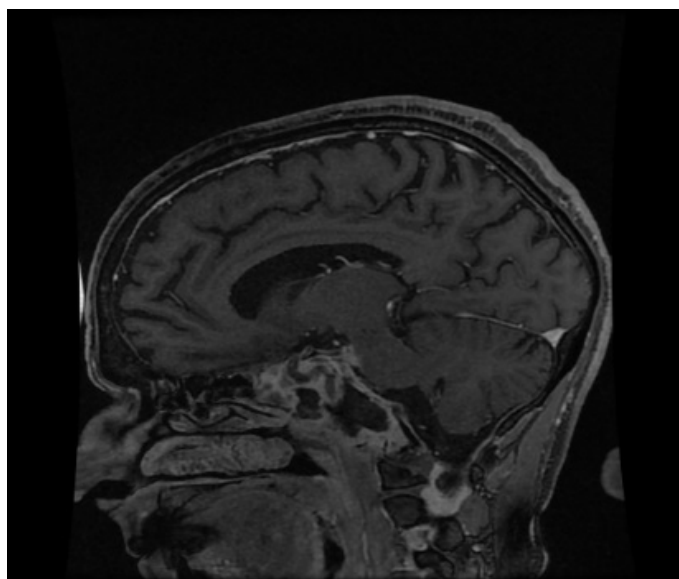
Contrast T1W MRI showing soft tissue enhancement seen at sphenoid sinus, clivus/base of skull.
